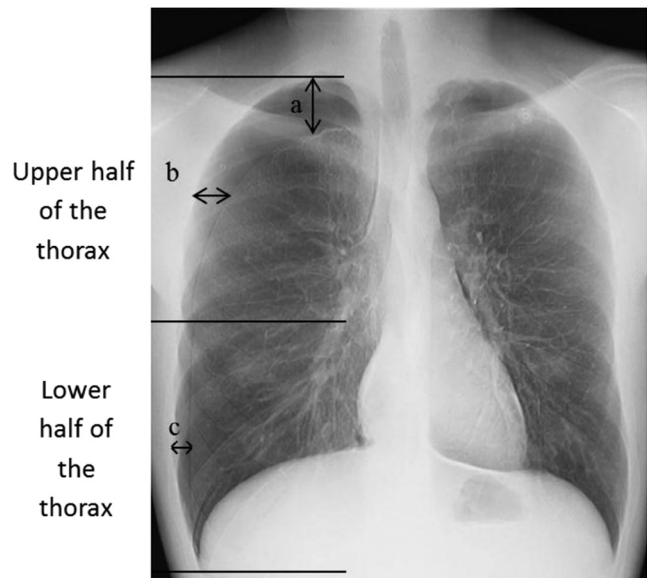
Chea/Rhoi method of estimating the volume of a pneumothorax. Chest DEBS radiography of an 18-year-old man, with chest pain showing a low-volume right apical-lateral pneumothorax. Three interpleural distances are measured: the first at the apex of the lung (a); the second at the midpoint of the upper half of the thorax (b); the third at the midpoint of the lower half of the thorax (c). From these three measurements an estimate of the volume of the pneumothorax in percentage is obtained by the formula: $4 + 9((a + b + c)/3)$. Here, $a = 1.7$ cm; $b = 1.3$ cm, $c = 0.6$ cm, that is, $4 + 9((1.7 + 1.3 + 0.6)/3) = 14.8\%$; this a small pneumothorax.
